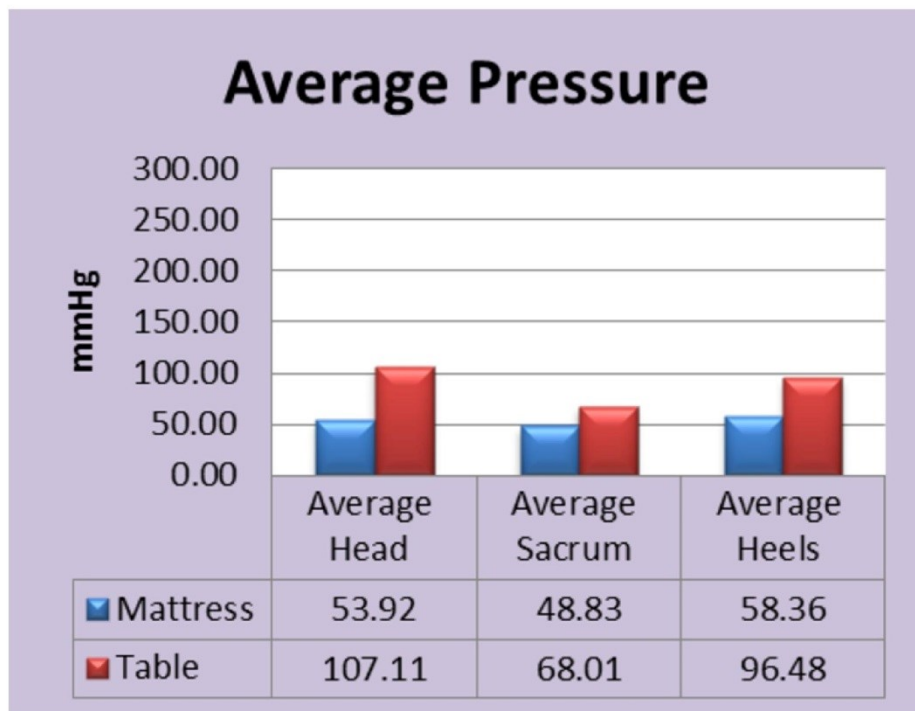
Graph comparing average pressure in mmHg for each of the jeopardy areas for both the mattress and the x-ray table. Inc standard deviation.
